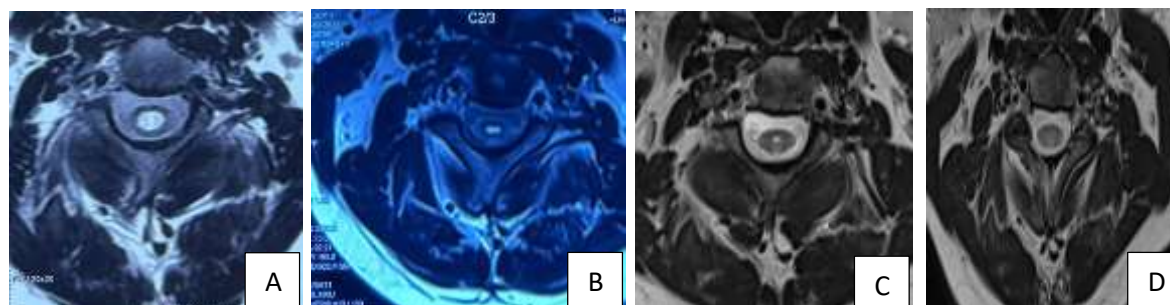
Axial T2W images showing hyperintense syrinx cavity in the cervical spinal cord from C2 to C3 at baseline (a), (b) and longitudinal follow-up MRI after vitamin B12 therapy (c), (d) showing near complete resolution of Syringomyelia in the cervical spinal cord
